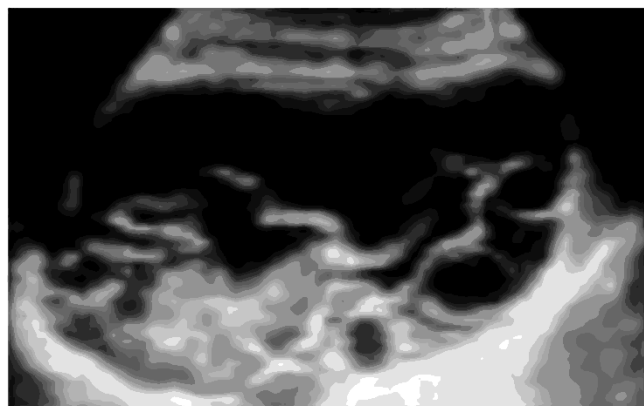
Sonogram. Echinococcal cyst type CE3
